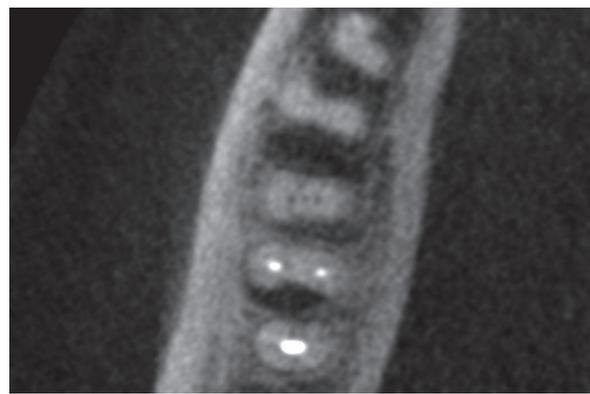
Axial CBCT section showing a middle distal canal in a mandibular first molar
